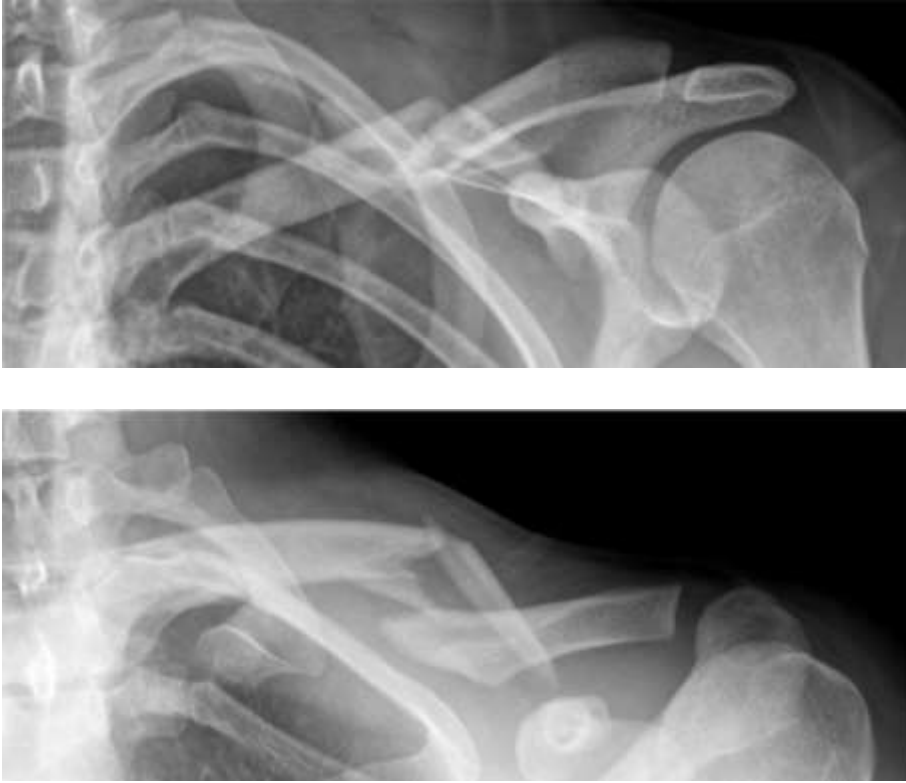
Midshaft fracture of the left clavicle in a 26-year old male, Robinson type 2B1. Two standard X-ray views are shown: anteroposterior (above) and 30 degree cephalad tilt (below). The latter clearly shows the value of an additional, 15-40 degree tilted X-ray to assess displacement.
